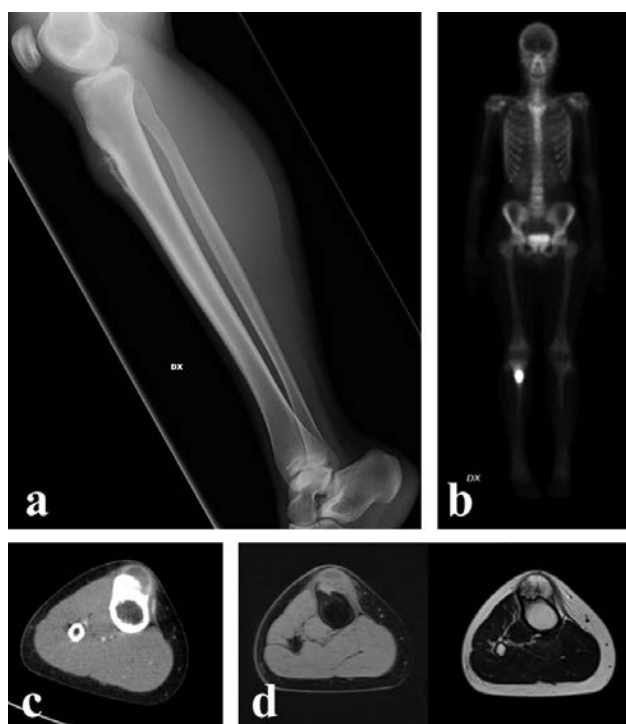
Osteosarcoma of the proximal tibia in a 20-years-old female. a) plain radiograph in lateral view shows destruction of the cortex with soft-tissue extension; b) bone scan demonstrates intense uptake in the proximal tibia without other suspicious lesions; c) Axial CT scan and d) axial MRI show a mass extended into the adjacent soft-tissue
